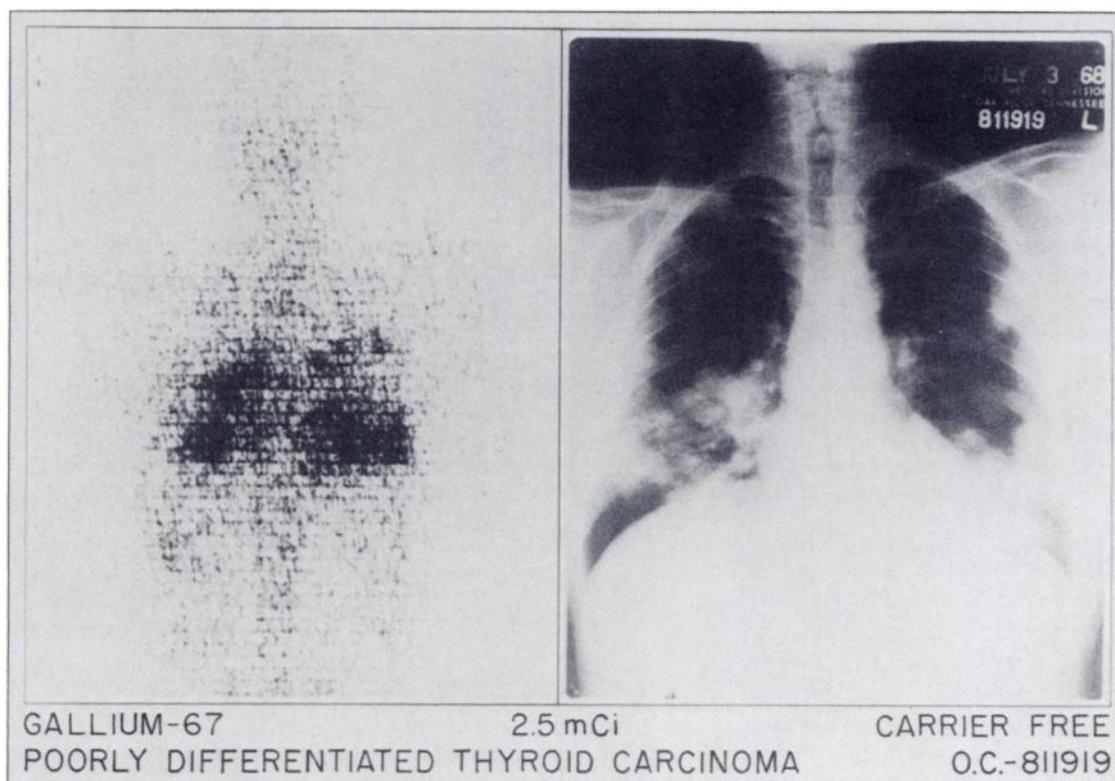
Case 2. (Left) Posterior photoscan of upper torso made on ORAU whole-body scanner 19 hr after administration of 2.5 mCi of ^{67}Ga citrate. No contrast enhancement was used. (Right) P-A chest x-ray of patient at time of scan.
